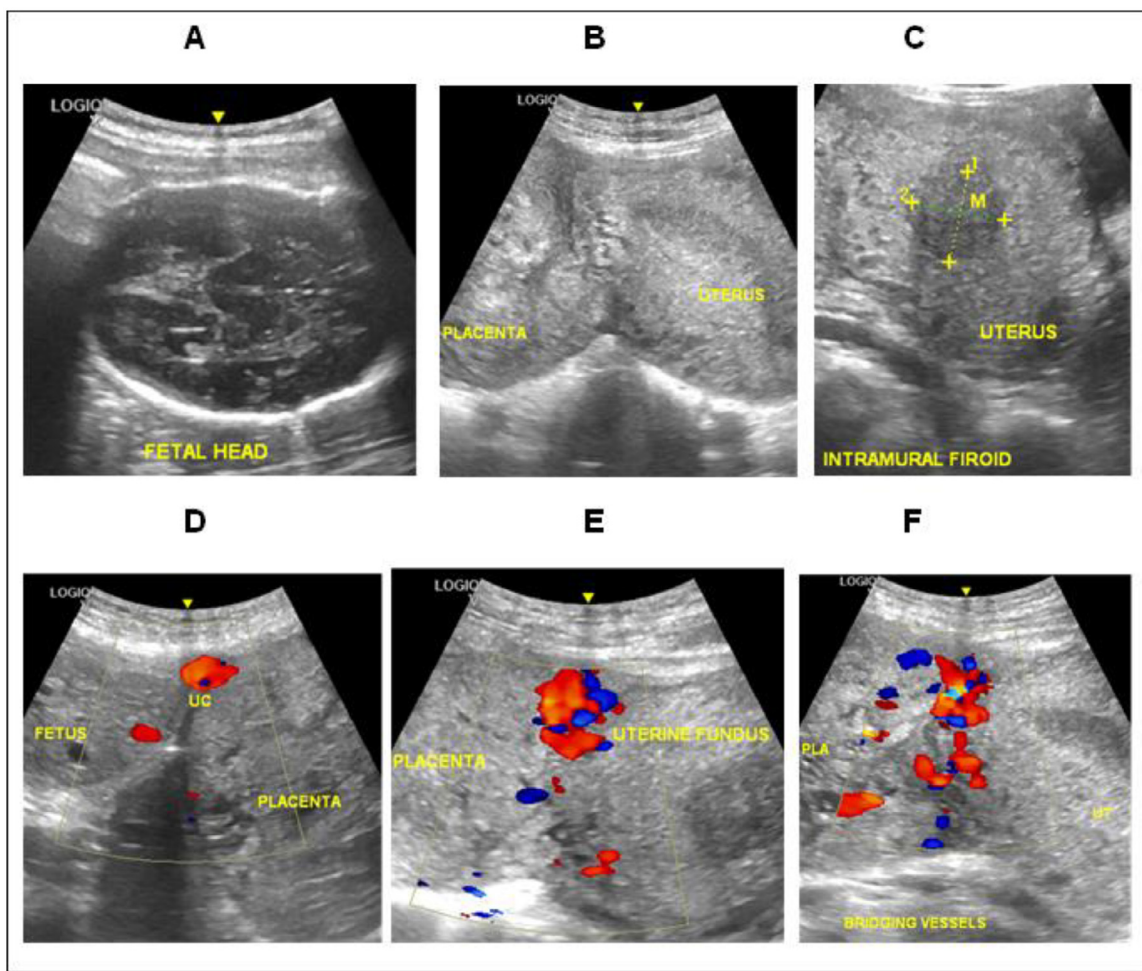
Grayscale and color Doppler ultrasound scan images obtained at 23 weeks gestation, showing the fetal head (A), implantation of the placenta at the uterine fundus (B), a small intramural fibroid (2.7 × 2.7 cm) (C), fetal abdomen and placenta (D), and placenta bridging vessels at the implantation site (E & F).
